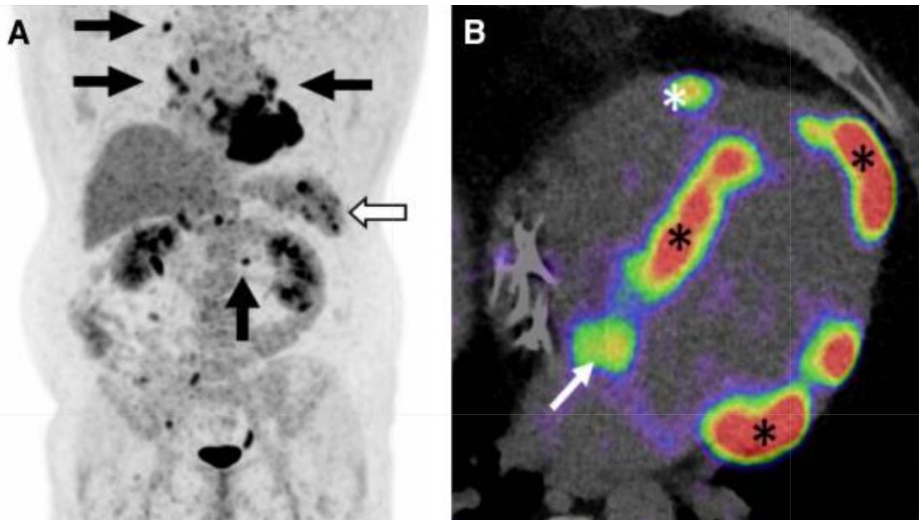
Whole-body PET revealing positive ^{18}F -FDG uptake in lymph nodes (arrows) and spleen (hollow arrow) (A). A 4-chamber PET/CT image displaying ^{18}F -FDG accumulation at various cardiac sites, including the LV septum, apex, and basal lateral wall (asterisks), the right ventricular free wall (arrow), and the interatrial septum (arrow) (B). *Adapted with permission of Oxford University Press from Eur Heart J, Cardiac sarcoidosis: phenotypes, diagnosis, treatment, and prognosis, Lehtonen et al. 2023, Copyright Clearance Center.*
